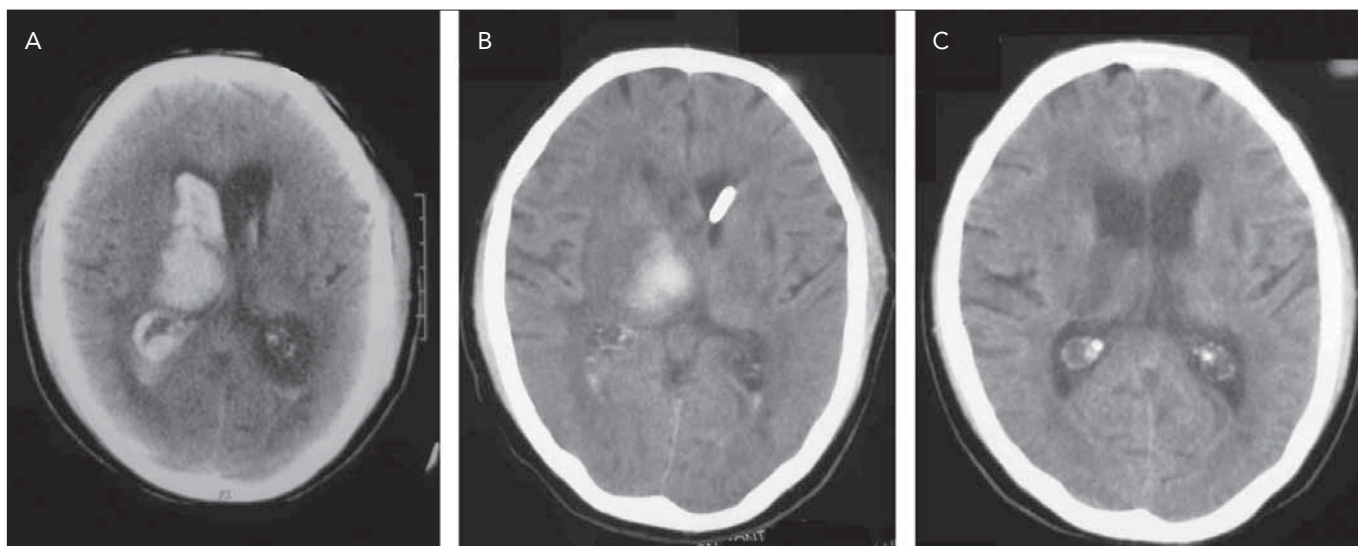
The right thalamic hematoma (A) seen at admission of the patient, and the following cranial computed tomography findings after placement of the EVDS catheter (B) and on the 19th day after admission (C).
